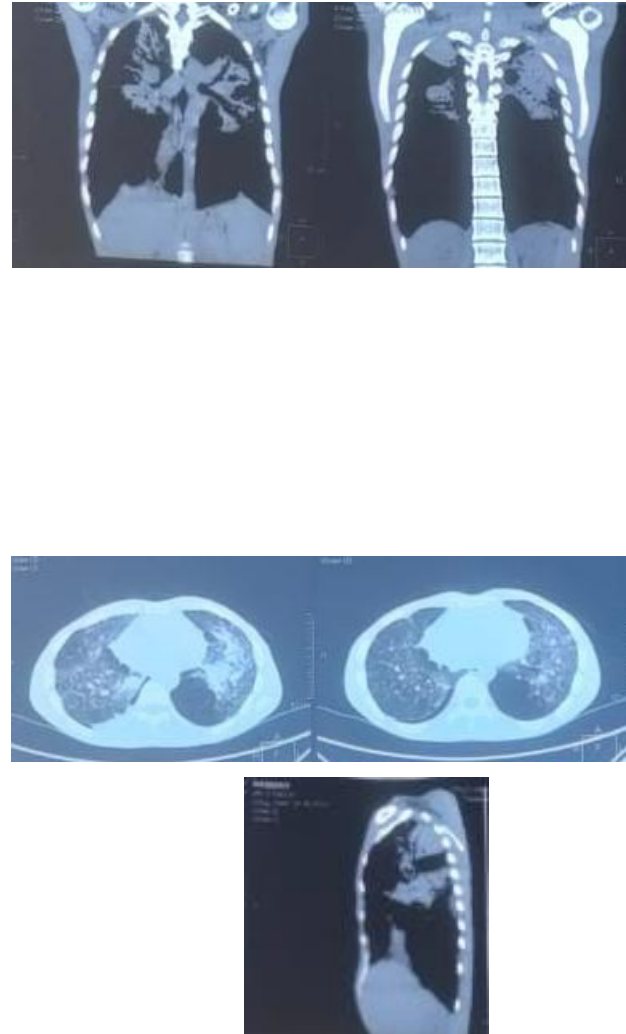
Non-Contrast HRCT Scan Thorax
